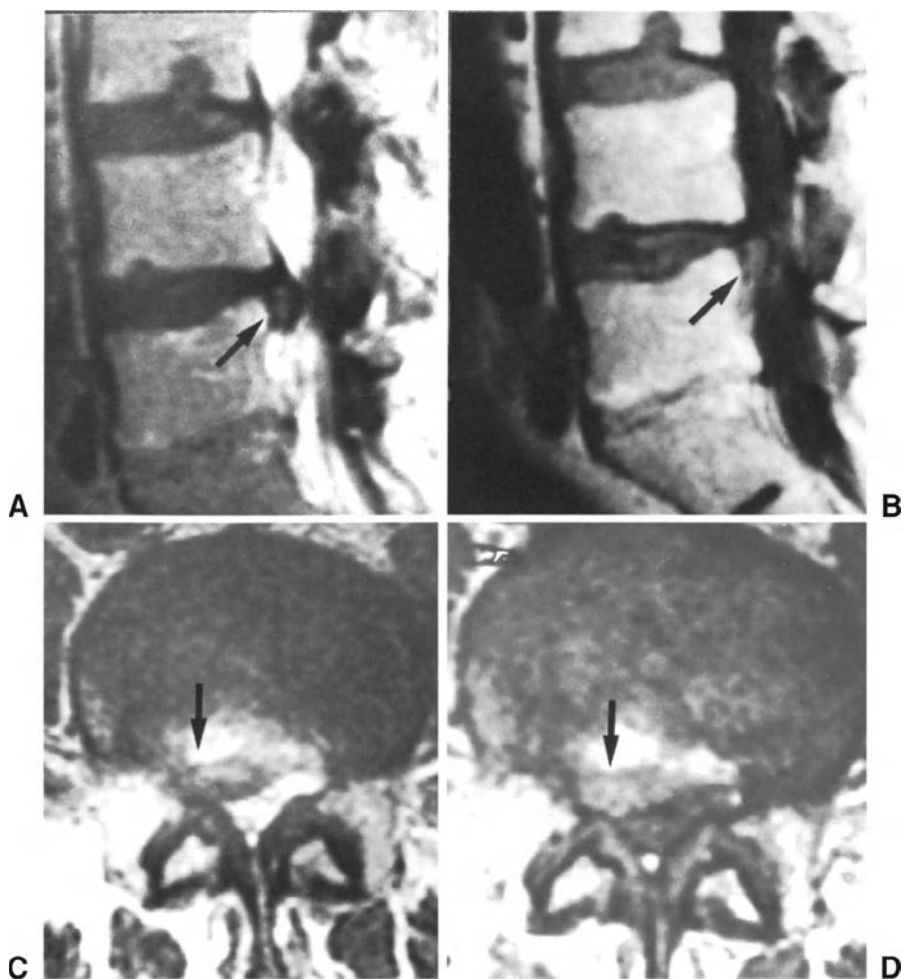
Disc herniation in a patient with combined spinal canal stenosis. (A) and (B) Turbo spin-echo T2-weighted and spin-echo T1-weighted sagittal MR images showing severe compression of the nervous structures at L4-L5 level due to an extruded disc herniation (arrows) in a spinal canal of small dimensions. (C) and (D) Spin-echo T2-weighted and T1-weighted axial MR images at L4-L5 level revealing a herniated disc on the right side (arrows). The patient underwent laminotomy and discectomy on the right.
